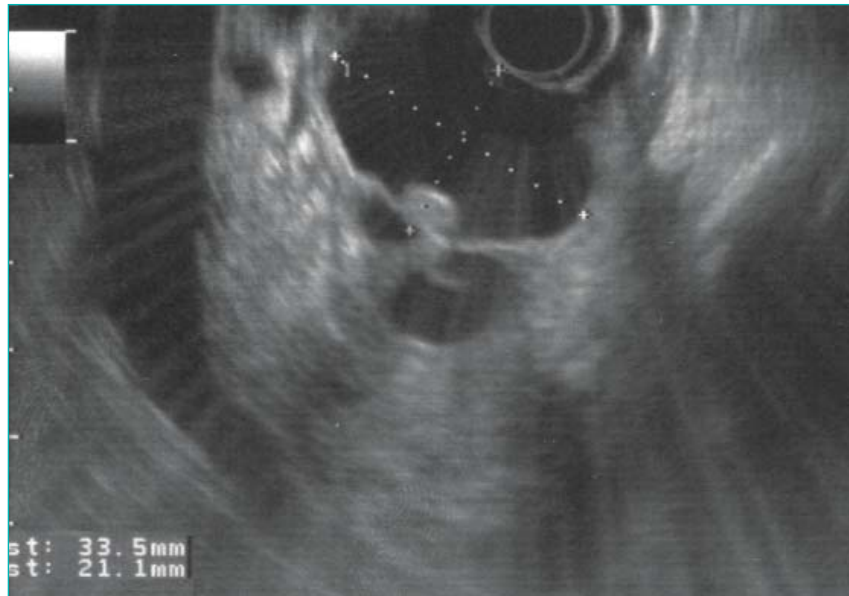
Endosonography from the duodenal bulb. Cystic lesion with septae and mural nodule within the head of the pancreas. The largest cystic space is marked with cursors.
